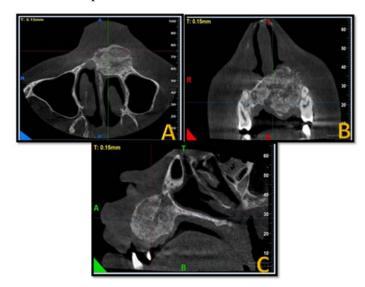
A-axial, B-coronal, C-sagittal view of CBCT shows an osteolytic, hyper dense, well circumscribed, mixed radio opacities in the anterior maxilla.
